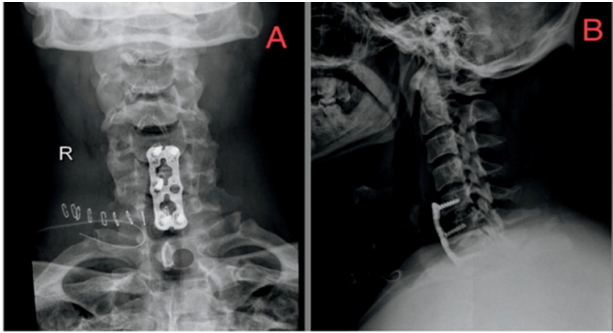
X-ray was taken on the 2nd Post-Operative day; Figure A: A-P view of cervical spine x-ray showed a satisfactory position of the hardware plate on the midline; Figure B: lateral X-ray of the Cervical Spine showed a satisfactory position of the plate, ion of the inter space with intervertebral cages.
